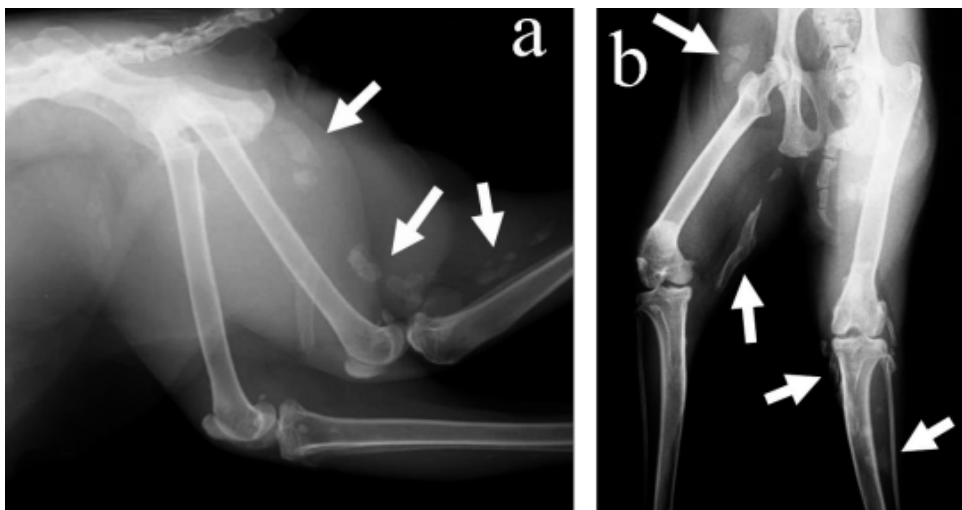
Lateral (a) and ventrodorsal (b) radiographic findings of the hindquarter. White arrows indicate multiple areas of well-defined ectopic mineralization in both the pelvic limbs.
